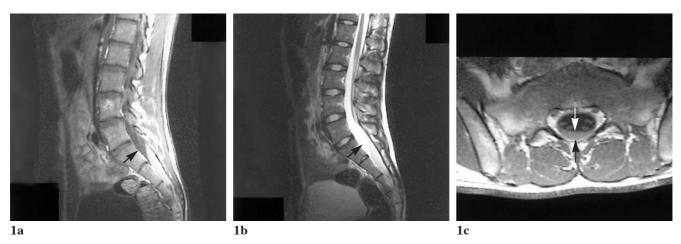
MRI of lumbosacral spine performed after admission. a. Sagittal T1-weighted image (T1WI, TR/TE: 350/14 msec) showed semilunar-shaped lesion (arrows) of high signal intensity at the posterior part of subdural space at sacral levels. b. Sagittal fast spin-echo T2WI (4000/99 msec) showed mildly hyperintense of the lesion (arrow). c. Axial post-contrast T1WI showed no significant enhancement of the lesion (arrows). The pictures were suggestive of subacute subdural hematoma.
